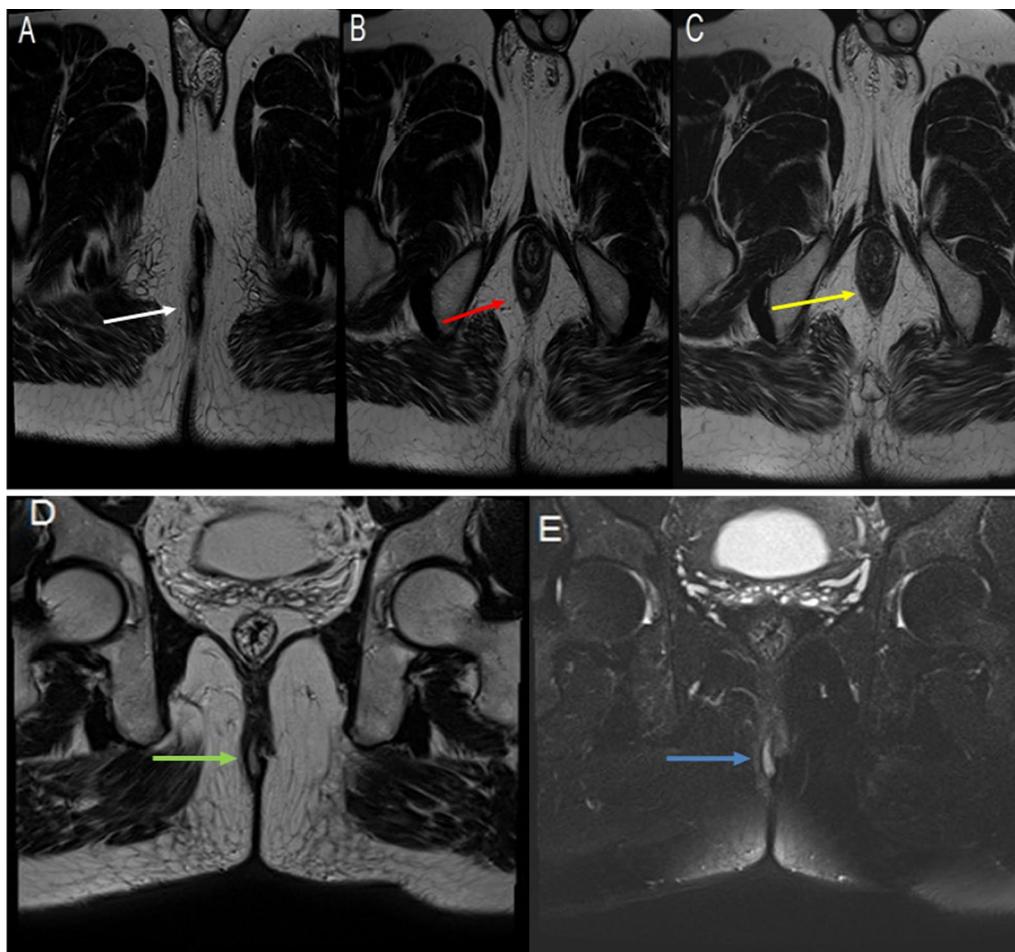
A 66-year-old male patient who presented with right perianal discharge. MRI examination after local injection of US gel through the fistulous tract revealed through axial T2 images (A–C): A External cutaneous opening of the fistulous tract (white arrow). B A non-branching simple tract at the right intersphincteric space (red arrow). C Internal mucosal opening connected to the anal canal at six o'clock (yellow arrow). Coronal T2 images showed: D the course of the linear intersphincteric tract (green arrow). E A coronal STIR image showed hyper-intense signal of the right intersphincteric tract (blue arrow). The final diagnosis was a right, grade I, intersphincteric fistula
